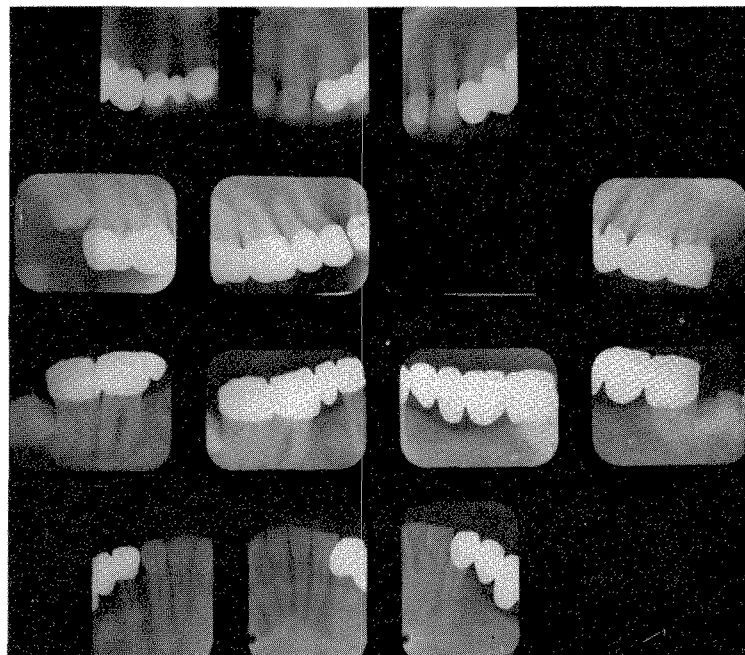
These are the last roentgenograms I was permitted to see. They were taken in March, 1961.
